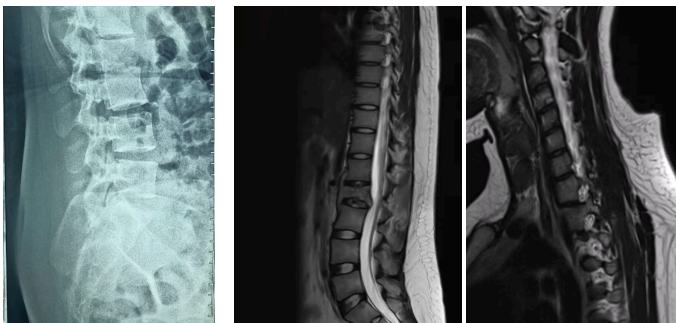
Plain Lumbosacral X-ray showing radiolucency of L2 vertebral body and MRI spine showing lesion involve over L2 vertebral body and pedicle with periverterbal soft tissue component and subcentimeter lesion over C4
